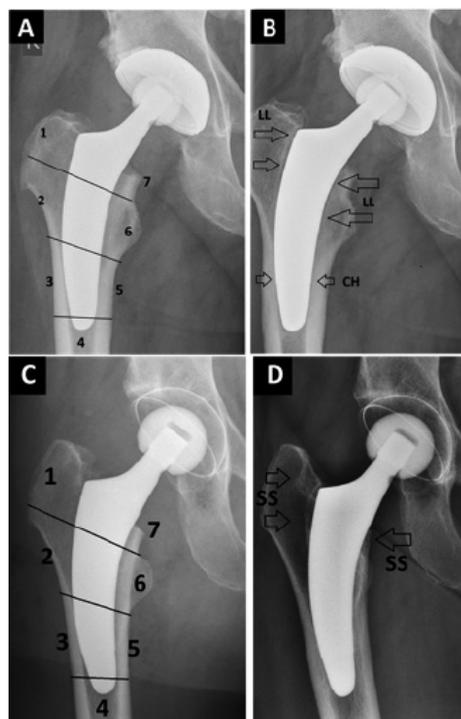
Radiographs of radiological alterations. (A) Postoperative radiograph with modified Gruen-zones, (B) 2-year follow-up with signs of lucent lines (LL) and cortical hypertrophy (CH). (C) Postoperative radiograph with modified Gruen-zones, (D) 2-year follow-up with signs of bony resorption and stress shielding (SS).
